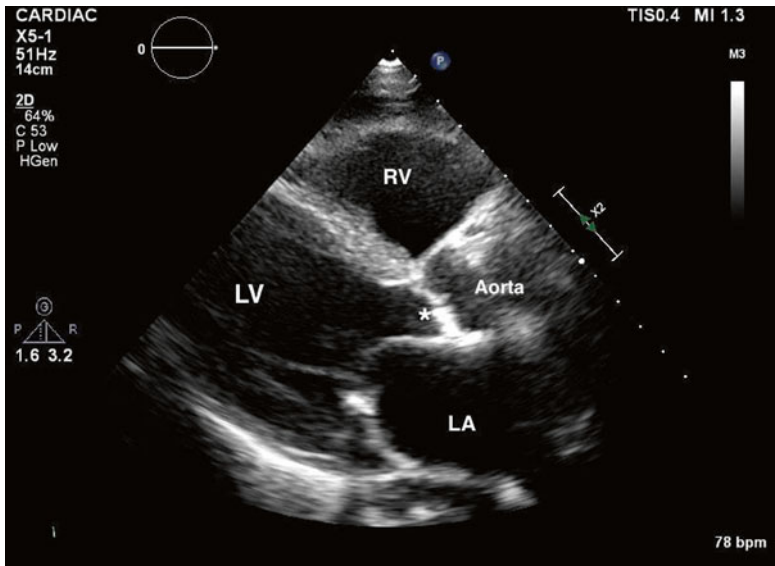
Parasternal long-axis view. The aortic valve (asterisk), as seen in cross section, is severely calcified. On cine imaging, minimal systolic leaflet excursion was noted. Left ventricle (LV). Right ventricle (RV). Left atrium (LA). Base of the aorta/aortic root (Aorta)
